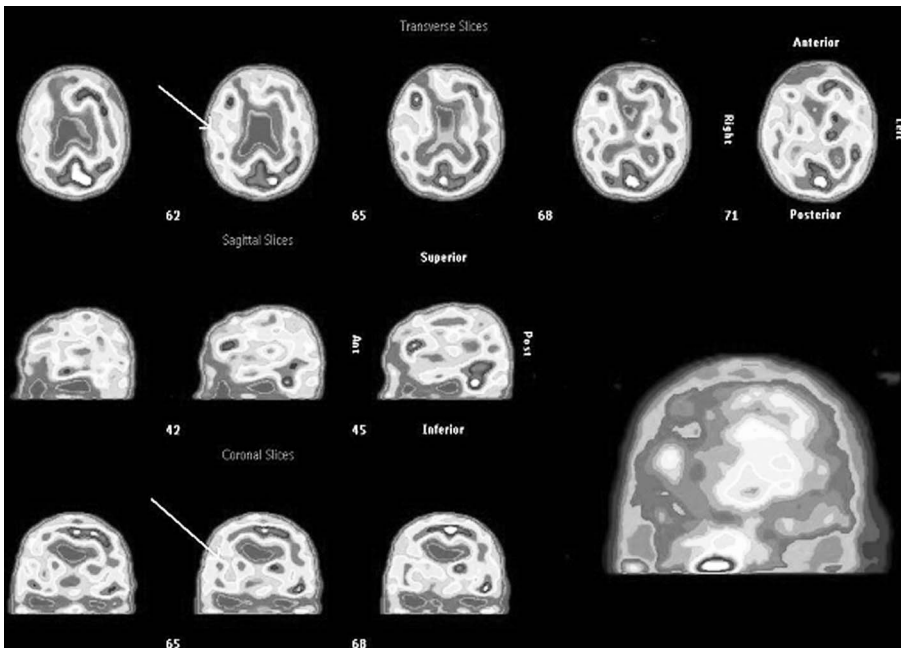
Single-photon emission computed tomography of the brain of patient Z. prior to endovascular intervention (the arrow marks the ischemic focus in the right hemisphere).
